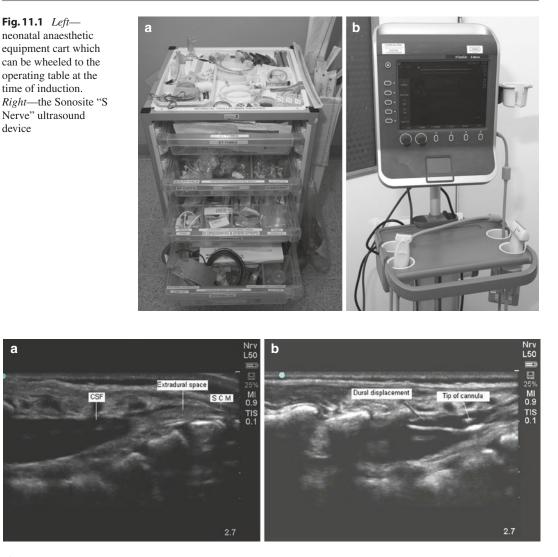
Caudal space ultrasound images in a term neonate. Top image (a) shows the dural sac terminating at L4. *CSF* cerebrospinal fluid; *SCM* sacro-coccygeal membrane. Bottom image (b) shows the tip of a cannula
